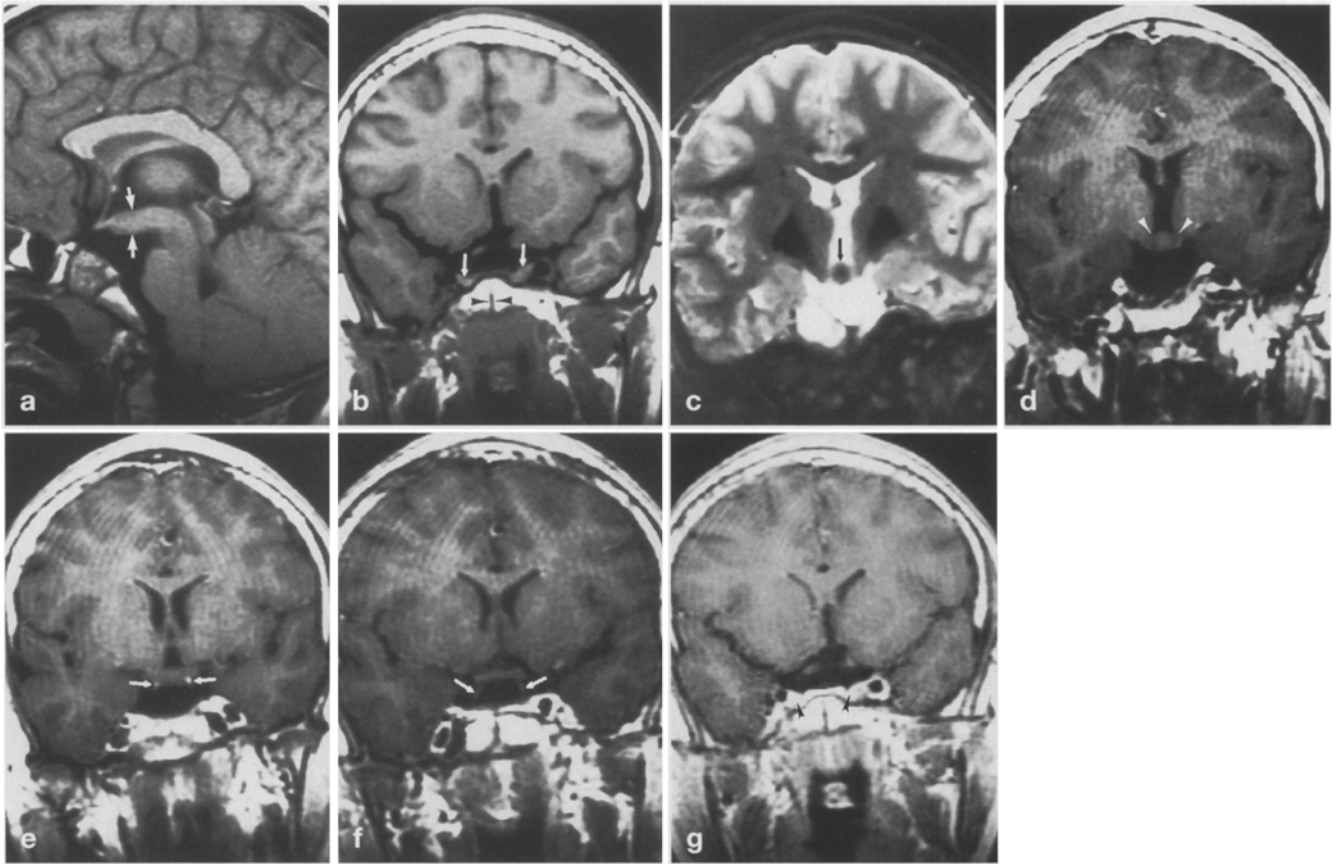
16-year-old girl with duplicated pituitary gland. a Sagittal T1-weighted image, 500/12/4 (TR/TE/excitations), shows a prominent hypothalamic mass (arrows) extending along the floor of the third ventricle from the brain stem to the posterior aspect of the optic chiasm. b Coronal T1-weighted (600/12/2) image shows a broad, shallow sella turcica with two pituitary fossae (arrows), and a midline cleft in the basisphenoid (arrowheads). c Coronal T2-weighted (2500/100/1) image reveals the T2 shortening in the midline hypothalamic mass (arrow). d–g Coronal contrast T1-weighted images (600/12/4) show two infundibular recesses separated by the nonenhancing midline hypothalamic mass (white arrowheads), leading to two enhancing infundibula (arrows), and two small enhancing pituitary glands (black arrowheads)
